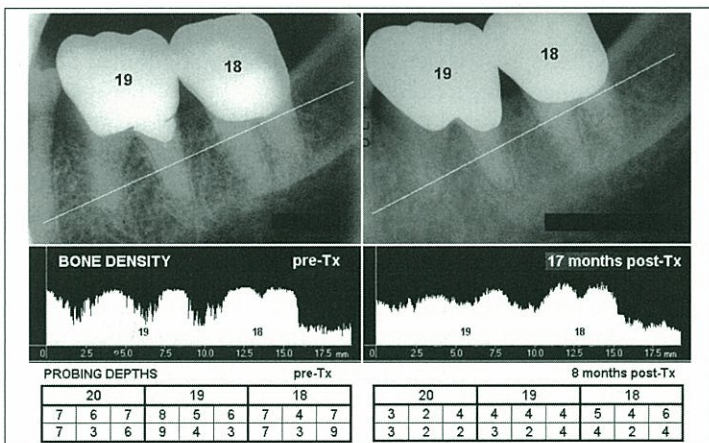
Case 2. Top: Radiograph showing close-up of teeth Nos. 18 and 19 before treatment (left) and 17 months post-treatment. Teeth were aligned and gray scales balanced using Emago software. The straight line drawn across the images indicates the location of the radiographic density profiles. Middle: Density profiles of line drawn on images. Bottom: Probing depths for teeth Nos. 20, 19, and 18 prior to treatment and at the 8-month follow-up exam.
